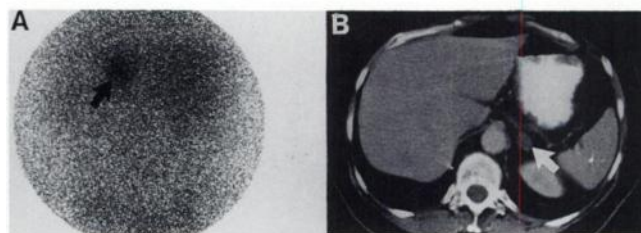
(A) Posterior NP-59 scintiscan depicts the remaining left adrenal cortex as a focal collection of ^{131}I radioactivity (arrow) in a patient nineteen years after right radical nephrectomy and adrenalectomy for hypernephroma (B) Abdominal CT identifies the left adrenal mass (arrow).
